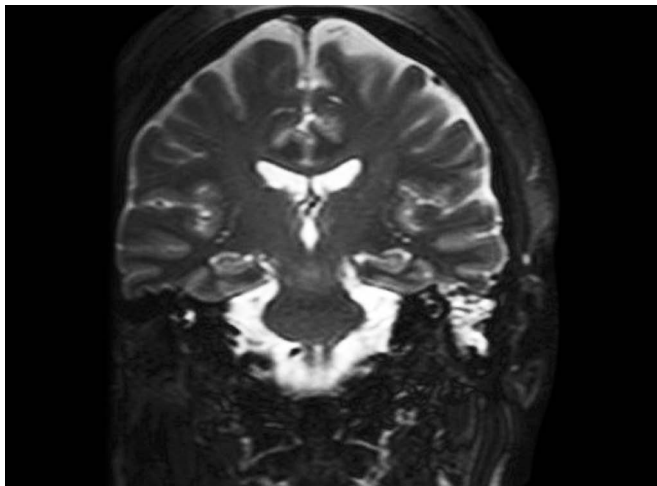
Coronal, T2-weighted magnetic resonance imaging (MRI) of a left ear encephalocele within the mastoid cavity and associated cerebrospinal fluid (CSF) leak. The posterior semicircular canal may be appreciated medial to the CSF-filled mastoid cavity.
